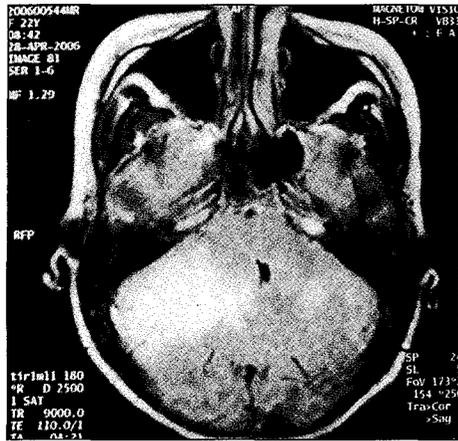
Axial MRI brain (FLAIR sequence) showing hyperintense lesion in the right cerebellum with compression of the 4th ventricle and brainstem
